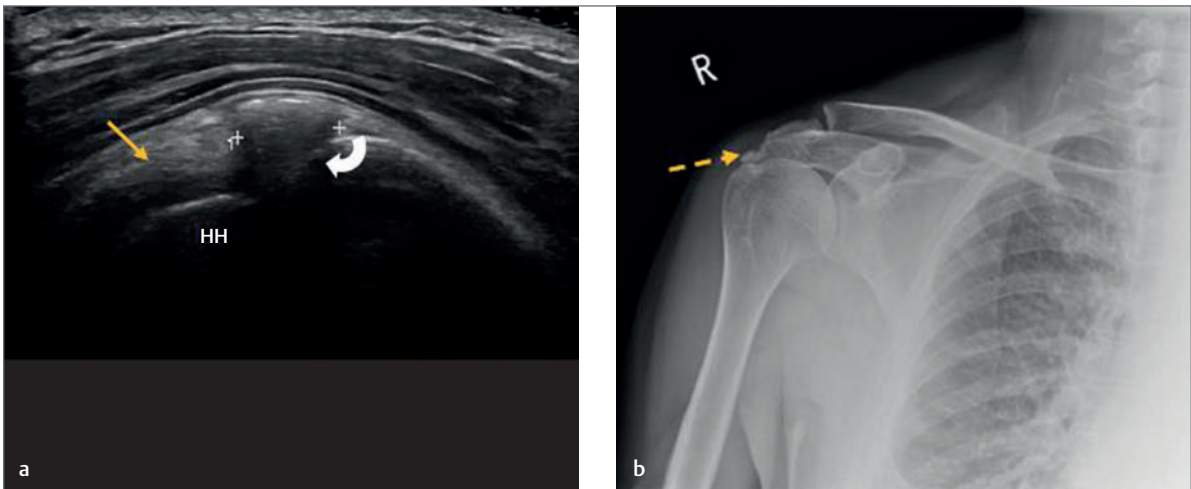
(a) Longitudinal image of the tendon of supraspinatus (yellow arrow). A relatively large calcific region measuring approximately 0.8 mm can be seen within the distal part of the tendon toward its insertion on the greater tuberosity (white crosses). Note the posterior shadowing (curved arrow). (b) X-ray of the same shoulder as in part (a) demonstrates the calcific foci (dashed yellow arrow). HH, humeral head.
